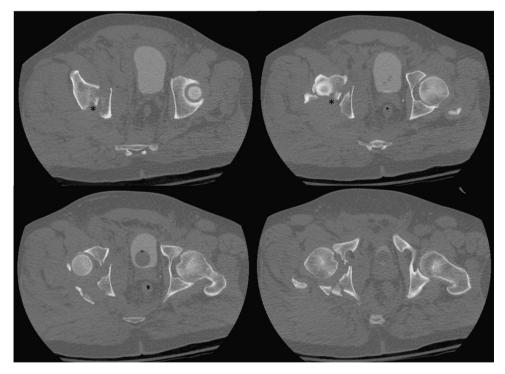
Computed tomographic scans showing the acetabular fracture dislocation from the anterior inferior iliac spine through the articular surface. Note the * marking the intervening articular fragment preventing reduction of the posterior column through skeletal traction.
